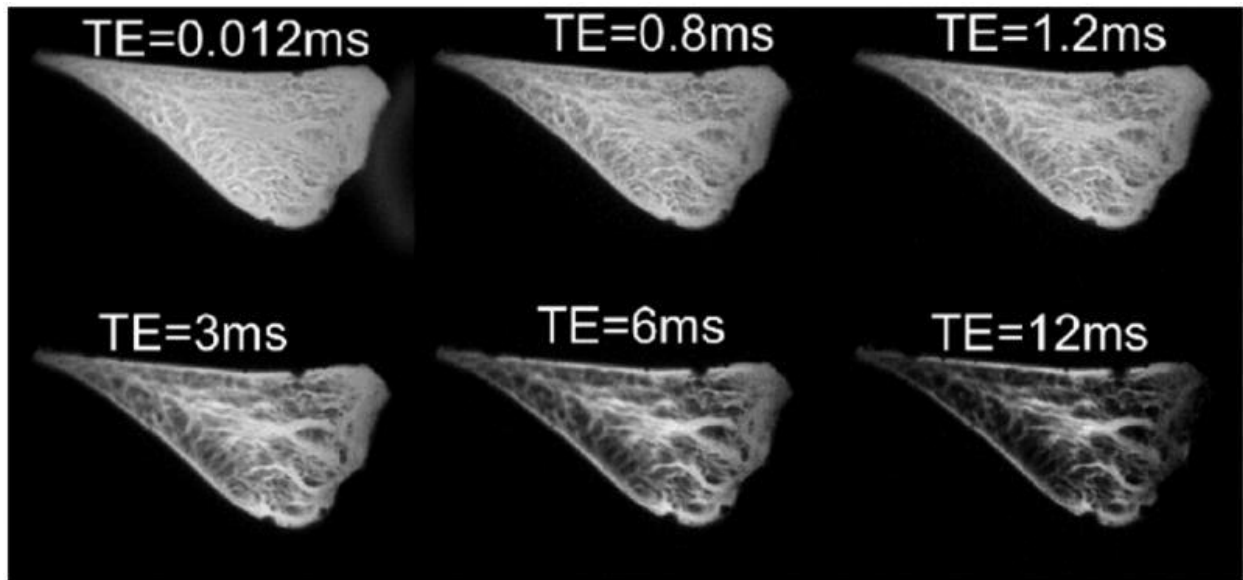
Menisci scanned by fat-saturated UTE-MRI with TE varying from 0.012 to 12 ms. Lower TEs present more enriched details on both the blood vessels and the collagen fibres in the meniscus. Reprinted from (108) (DOI link: <https://dx.doi.org/10.1097%2FRMR.0b013e31823cceb>). Permission is granted by *Wolters Kluwer Health, Inc.* for reuse in a thesis/dissertation.
